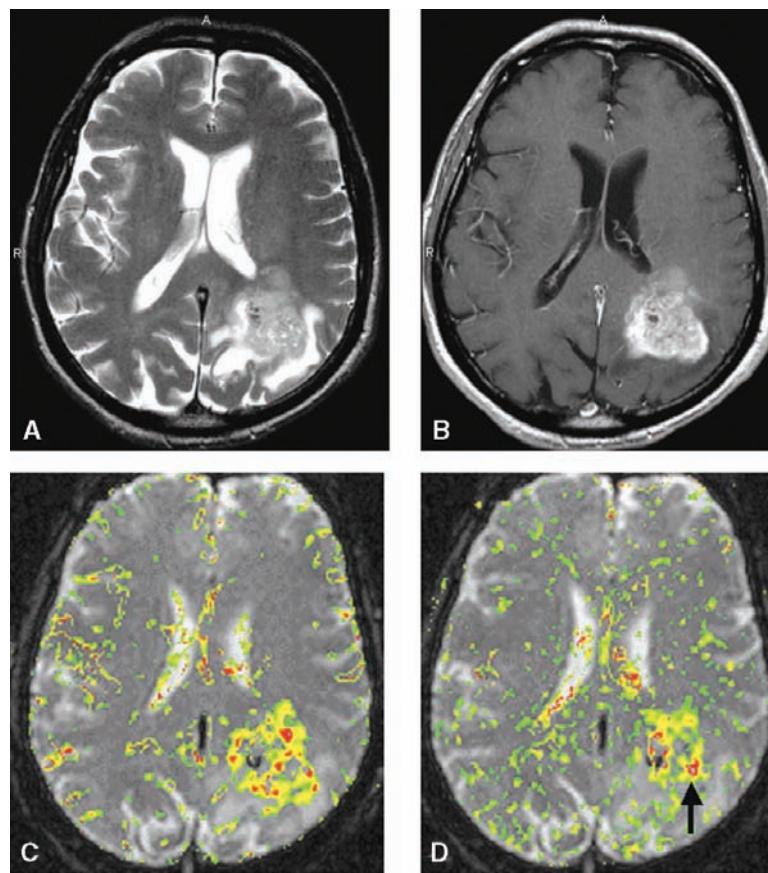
A 72-year-old man with a glioblastoma multiforme (WHO Grade IV). (A) T2-weighted image with a left parietal lesion demonstrating mass effect, edema, and signal heterogeneity, features of a glioblastoma multiforme. (B) T1-weighted postgadolinium image with extensive heterogeneous contrast enhancement. (C) Gradient-echo axial DSC MRI with rCBV map shows markedly elevated perfusion within the lesion. (D) SD25 color overlay map suggesting markedly elevated vascular permeability. Note that the areas of highest rCBV elevation do not correspond exactly with the regions of highest vascular permeability (arrow). Abbreviations: rCBV, relative cerebral blood volume; DSC MRI, dynamic susceptibility contrast MRI. Source: From Ref. 28.
